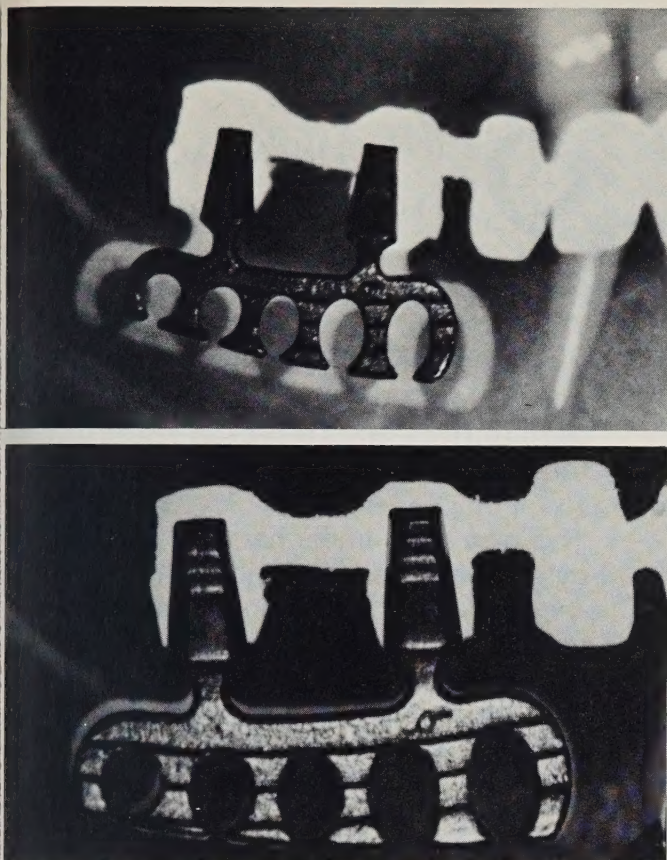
Roentgenographs of endosseous implant in mandible with duplicate metal implant placed over image. A. Section of panograph showing extreme distortion of image. B. Intraoral film made with parallel technique showing only slight distortion. (Prosthesis courtesy of Dr. J.W. Smerke).
